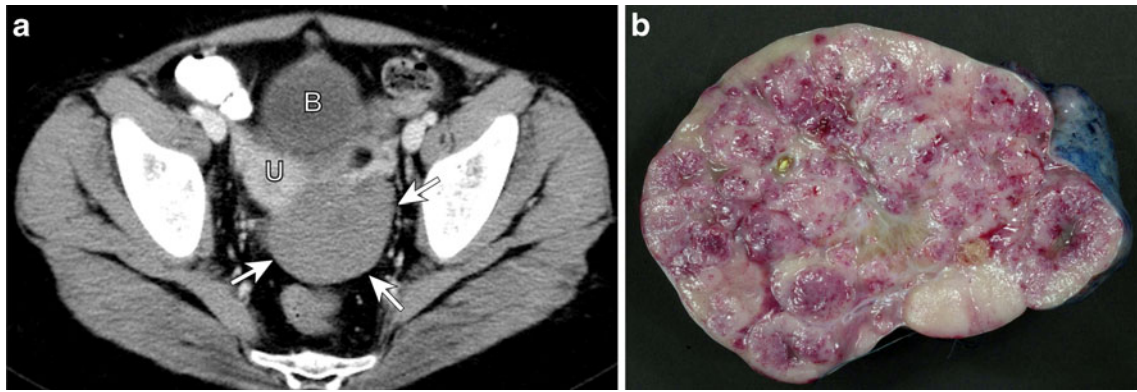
Incidentally discovered dysgerminoma with coexistent gonadoblastoma in a 12-year-old girl with common variable immunodeficiency hyper IgM syndrome. a Axial CT image shows a relatively homogeneous enhancing soft-tissue mass (arrows) originating from
